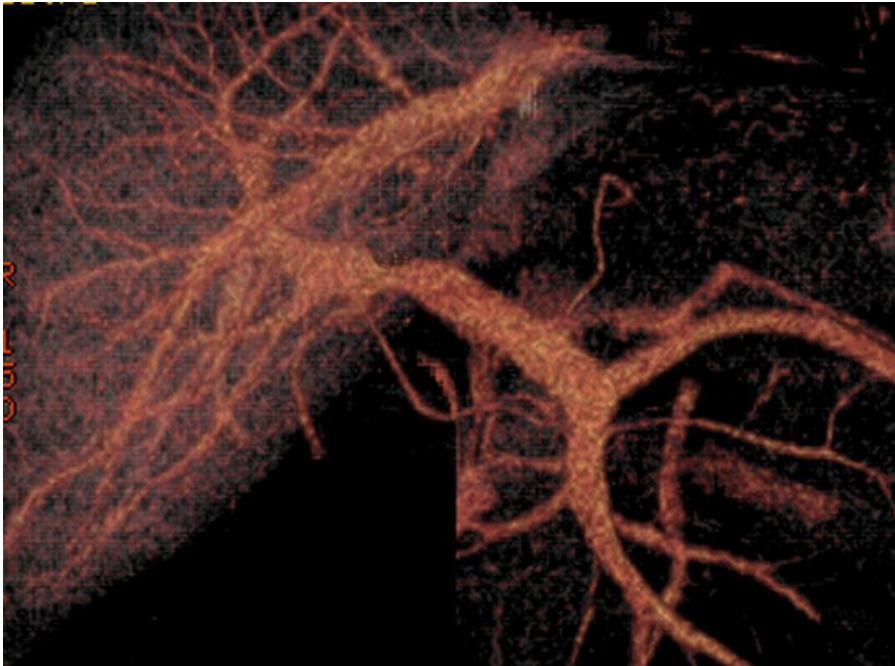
Spiral computed tomography. Bismuth-Corlette type IIIb perihilar cholangiocarcinoma with portal vein invasion.
